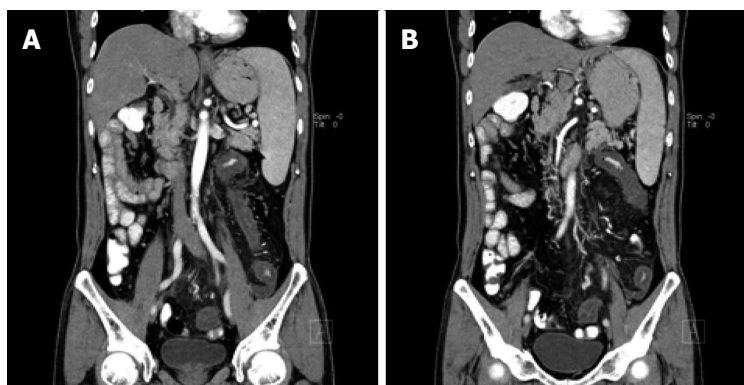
Magnetic resonance imaging of the abdomen and pelvic showed a stenosis of the mesenteric inferior artery branch (A) and thickening of the mesenteric inferior artery branch walls (B). The image shows a diffuse lesion of the left colon suggesting ischaemic injury.
